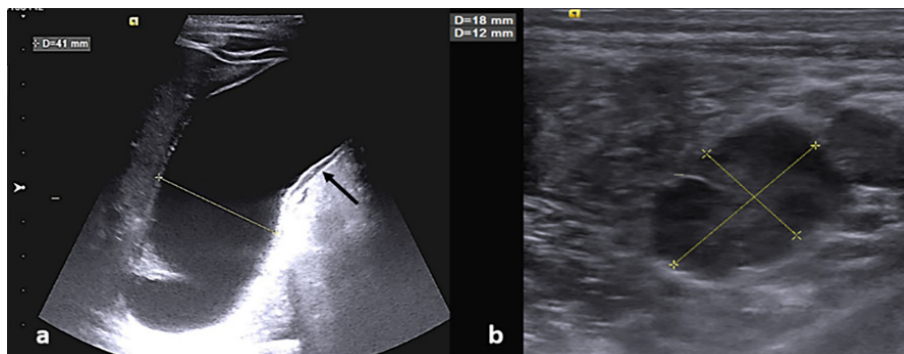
Multisystem inflammatory syndrome in children in a 4-year-old boy with abdominal pain and low-grade fever 4 weeks after infection with SARS-CoV-2. Abdominal ultrasound images reveal gallbladder distension (a), mild wall thickening (black arrow in a), and multiple mesenteric reactive lymphadenopathies (b).
